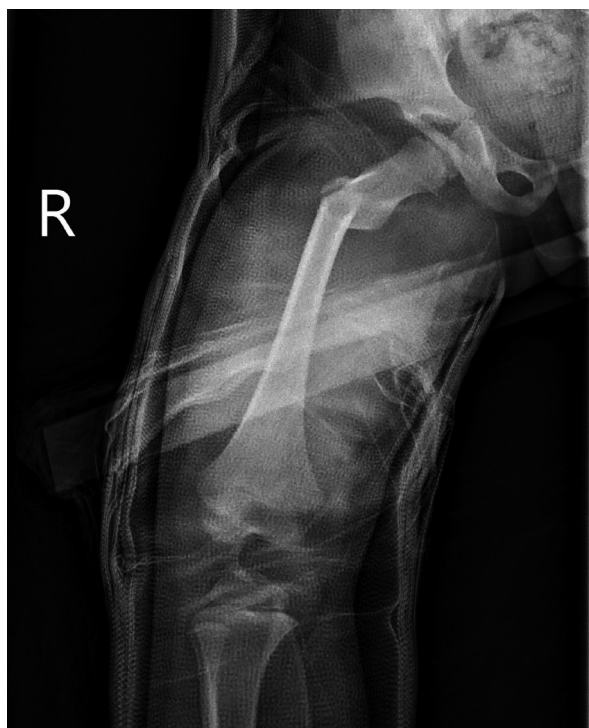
After initial closed reduction and hip spica, roentgenogram revealed a varus deformity of the femur with slight anterior bending near the subtrochanteric area.
